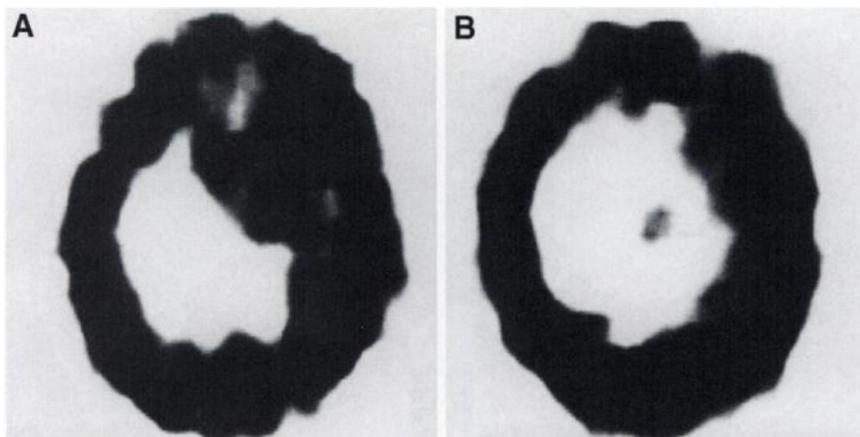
Brain hematoma patient (40-y-old woman) 3 d after traffic accident. CT scan revealed hematoma in left frontal area. (A) Early SPECT brain image shows high uptake of radioactivity in left frontal area. (B) Delayed SPECT brain image shows lower uptake of radioactivity in same area as in (A). Retained index = 0.60.
